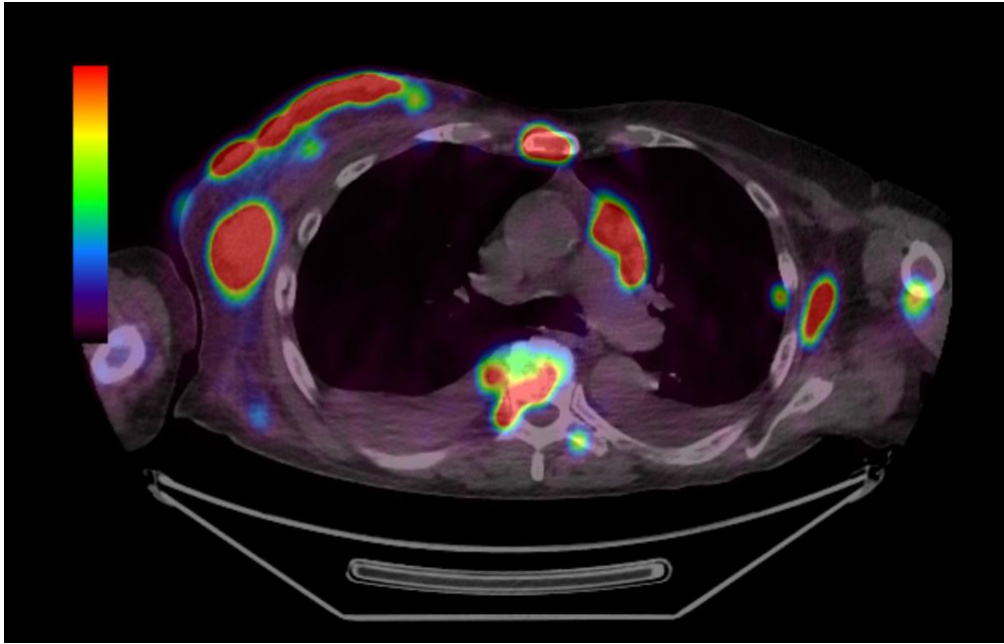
PSMA PET scan showing high avidity in accordance to right chest wall cutaneous lesions. (*PSMA*, prostate specific membrane antigen; *PET*, positron emission tomography)
